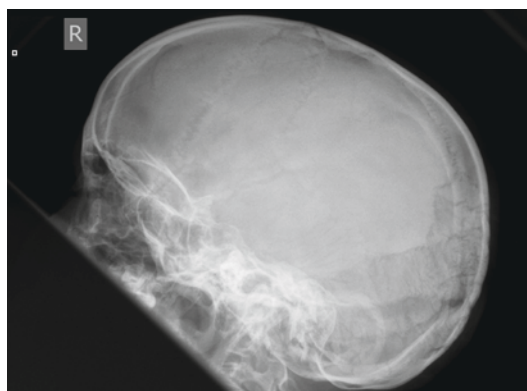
Lateral skull radiograph showing basilar invagination.
